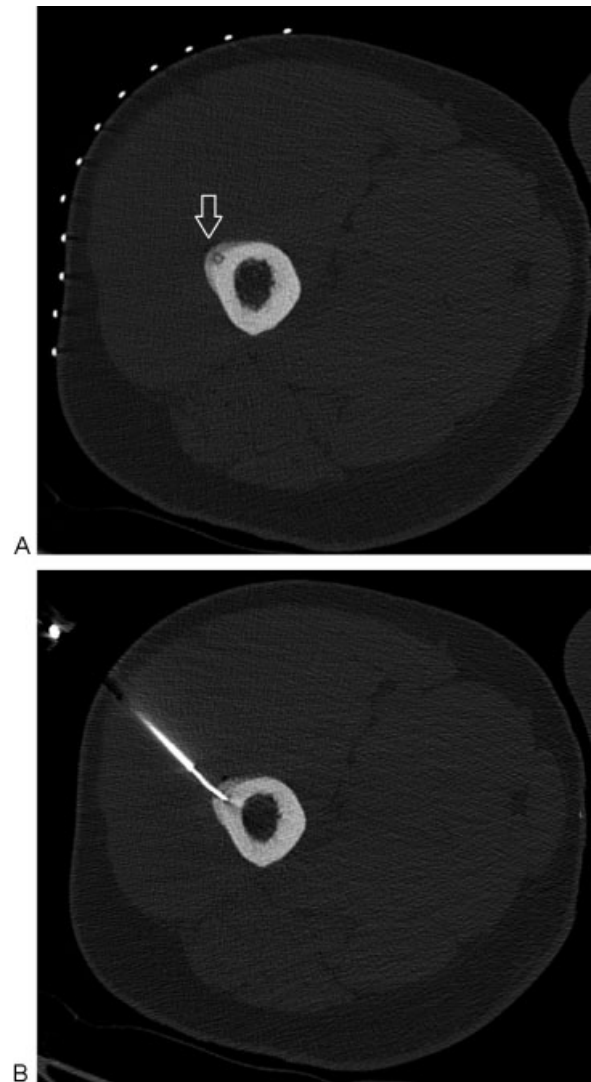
A 44-year-old man with recent onset radiating hip to mid-thigh pain. (A) Axial CT with cortical thickening and lucent lesion with central sclerotic nidus consistent with osteoid osteoma (arrow). Overlying skin grid used during lesion targeting for safe access window. (B) Initial biopsy needle for tissue sample was inserted, and the RFA probe tip was advanced into the central portion of the lesion. CT, computed tomography; RFA, radiofrequency ablation.
